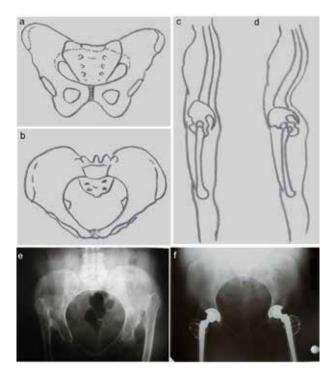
In bilateral cases, the posterior shift of the femoral head increases the anterior tilt of the pelvis, which is compensated by hyperlordosis of the lumbar spine (a, c: normal; b, d: pathologic). Because of hyperlordosis, the pelvis is turned forward (d). In the plain AP radiograph, the pelvis can look like the "inlet view" (b). This structural deformity even without bony changes does not adequately improve after surgery despite the new location of the joints (e: preoperative radiograph, f: postoperative radiograph).
